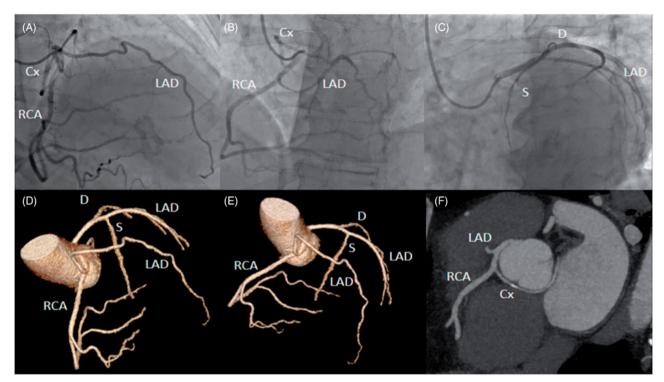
Invasive coronary angiography of the coronary anomaly in right anterior oblique (panel A) and left anterior oblique projection (panel B–C) with corresponding three-dimensional reconstruction from a 192 slice dual-source CT coronary angiography (panel D–E) with a maximum intensity projection (panel F).
